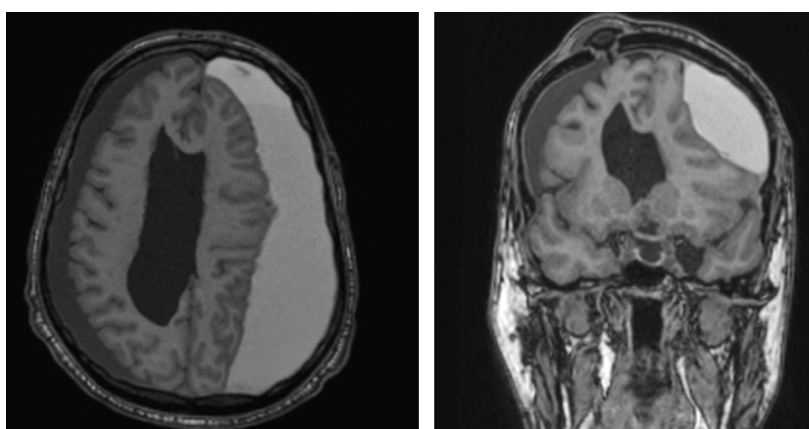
MRI sequences axial/coronal 3 months after ETV with bilateral chronic subdural hematomas (chSDH) with mass effect.
